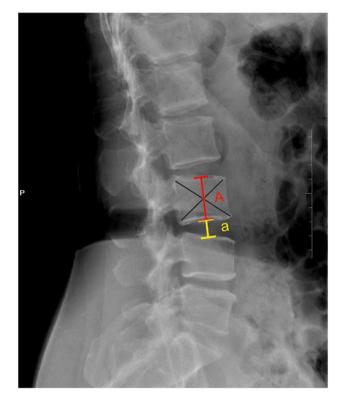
Disc height index (DHI) on X-ray. DHI = a/A
